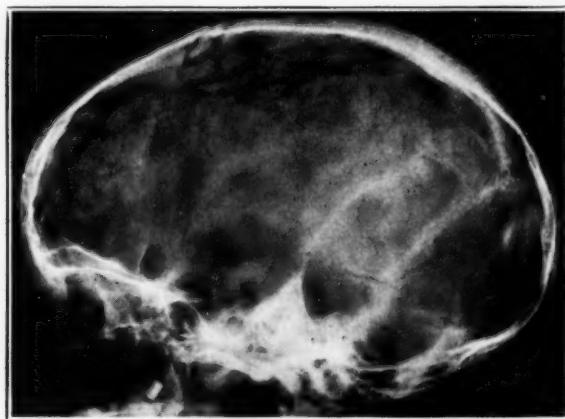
(case of Cohen).—Typical and pathognomonic roentgenologic appearance of the skull associated with congenital atresia of the foramina of Luschka and Magendie. Note the position of the lateral sinus on the parietal bone and the enormous posterior fossa. (This roentgenogram is reproduced by permission of Dr. Ira Cohen, who loaned us the original film).
